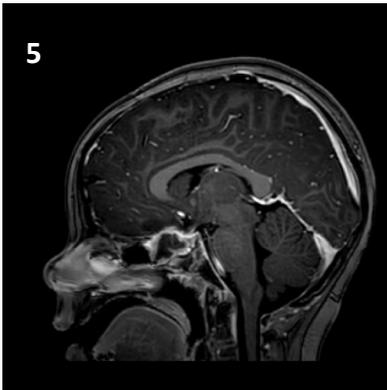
Sagittal contrasted T1 MRI demonstrating decompressed optic chiasm with resolving sellar granulation tissue and packing material, without evidence of recurrence
